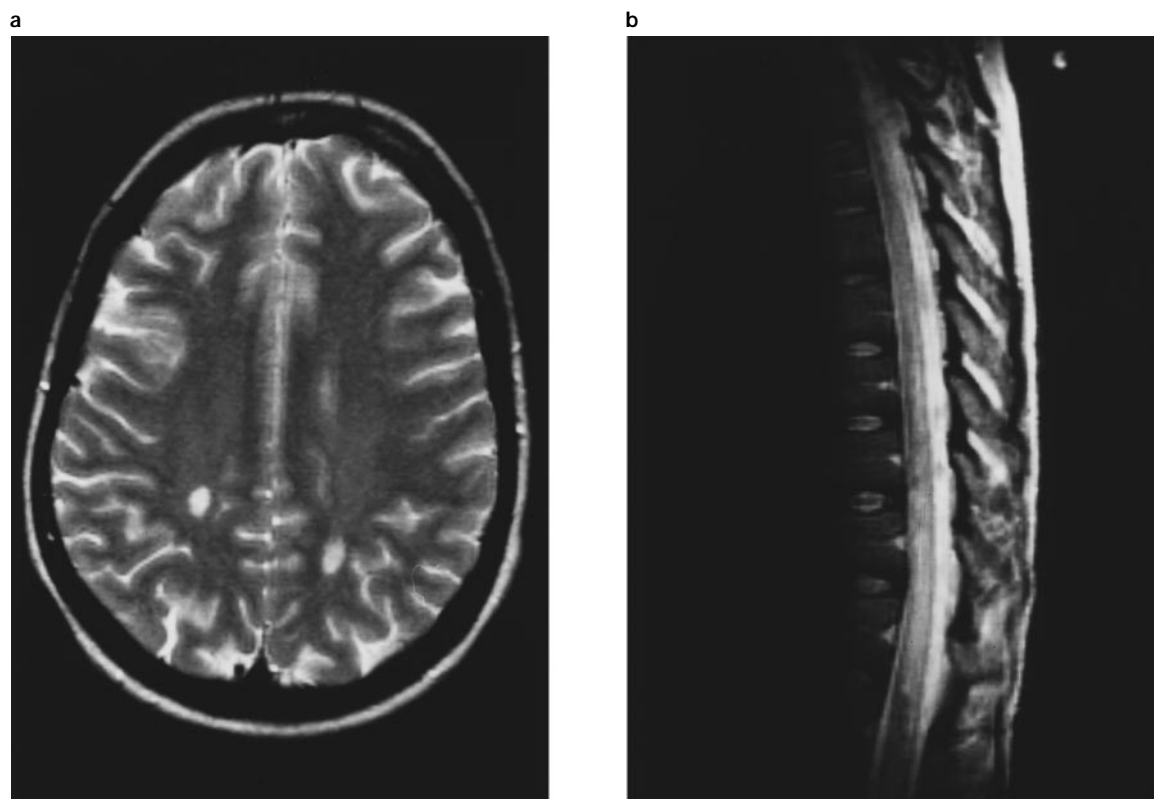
MRI-scan of cerebrum (a) and spinal cord (b) in patient 1 with large areas of increased signal periventricularly (a) and from T6 to T12 (b).
